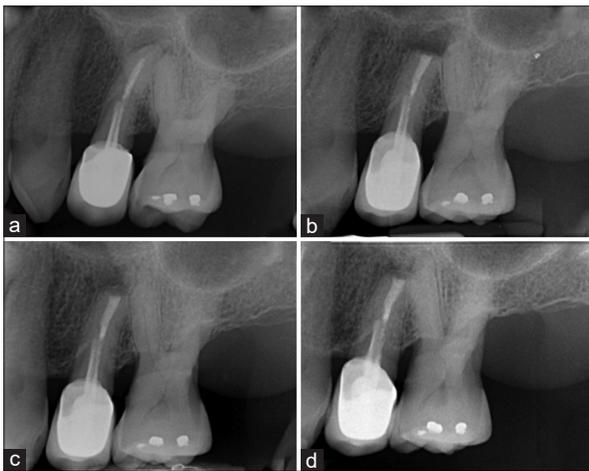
(a) Preoperative radiograph of the Bio-MA retrofilling of maxillary left first premolar with symptomatic apical periodontitis and persistent periapical pathosis, (b) Immediate postoperative radiograph, (c) 6-month recall radiograph, and (d) completely “healed” in 13-month recall radiograph
